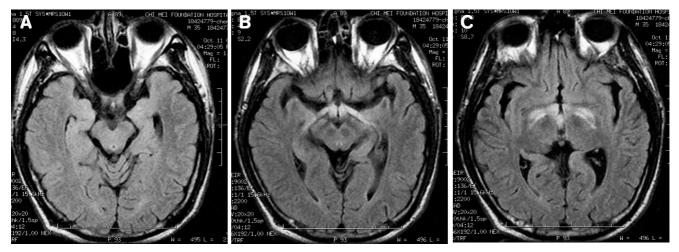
Sequential axial magnetic resonance imaging of the head demonstrating abnormal high signal in optic chiasma (A), bilateral optic tracts (B) and lateral geniculate bodies (C) in FLAIR images
